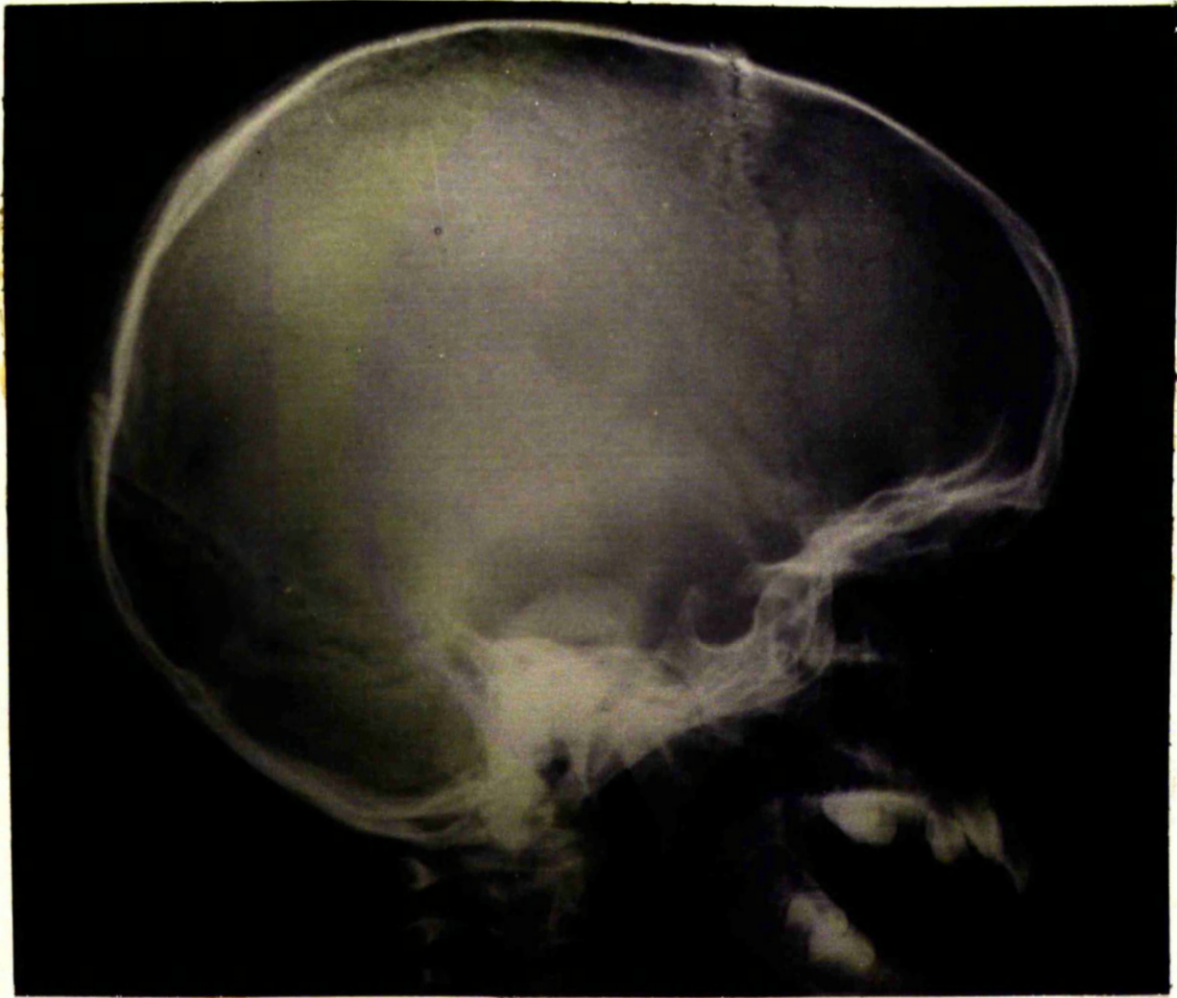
X-ray of skull showing the enlarged and deep sella turcica.
